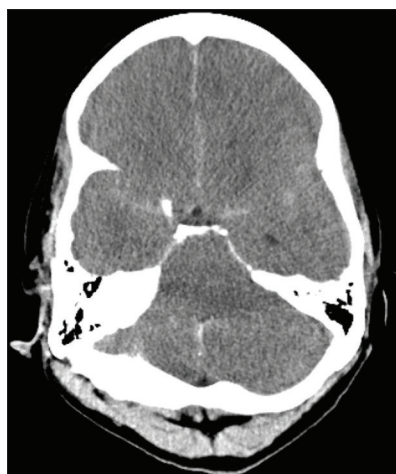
Computed tomography demonstrating diffuse hyperdensity within the subarachnoid space in a patient with pseudosubarachnoid hemorrhage.
